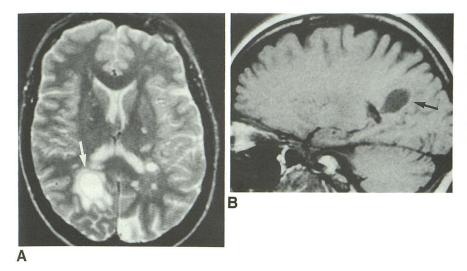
A*, (2740/100). Case 1, T2-weighted axial section, showing multiple high signal lesions typical of demyelination. A ring of low signal intensity (*arrow*) is seen in a large lesion in the paratrigonal white matter of the right hemisphere.
